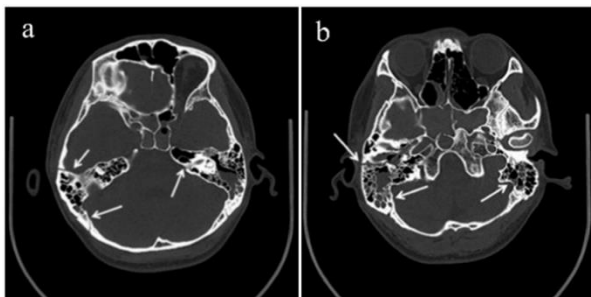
(a,b): High-resolution CT scan showing bilateral temporal bone fractures
